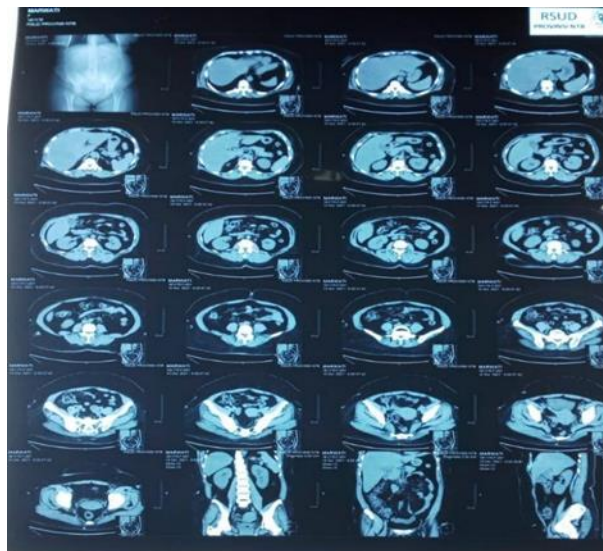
Abdominal computed tomography scan on patient showed cystic mass on her right lobe of the liver
